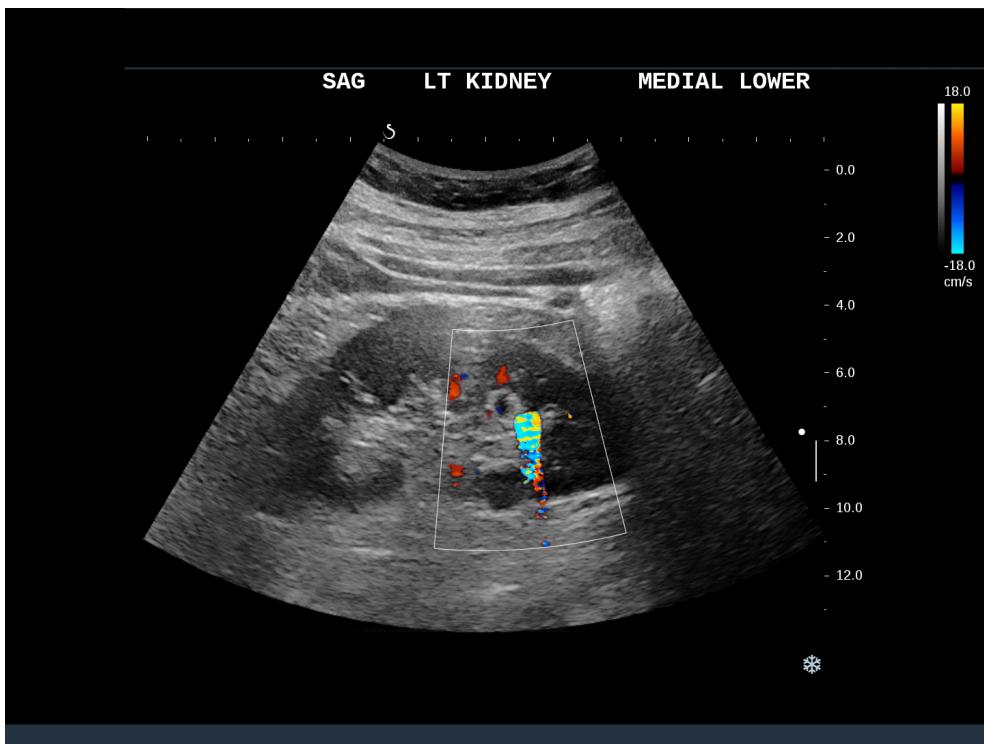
Twinkle Artifact. In this renal ultrasound with doppler flow, a small renal calculi causes the appearance of a twinkle artifact, which manifests as a focus of alternating colors behind the reflective stone.
